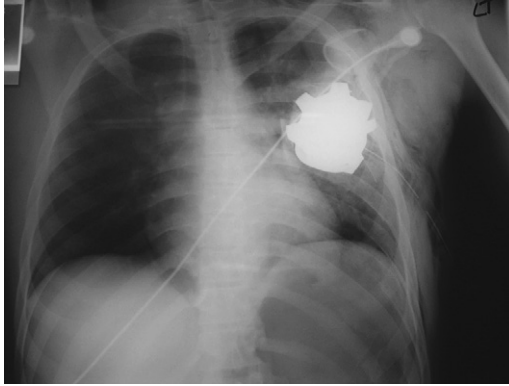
Portable AP chest radiograph of patient who was hit during a firefight. The radiograph generated initial concern regarding the possibility that the patient had unexploded ordnance in his chest.
